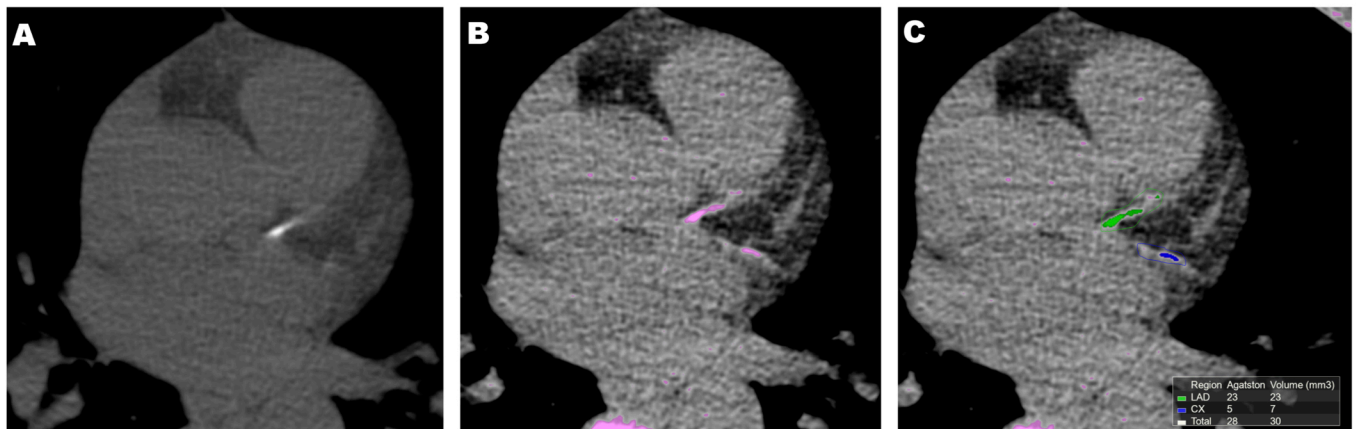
Computed tomography being used to calculate coronary calcium score.
